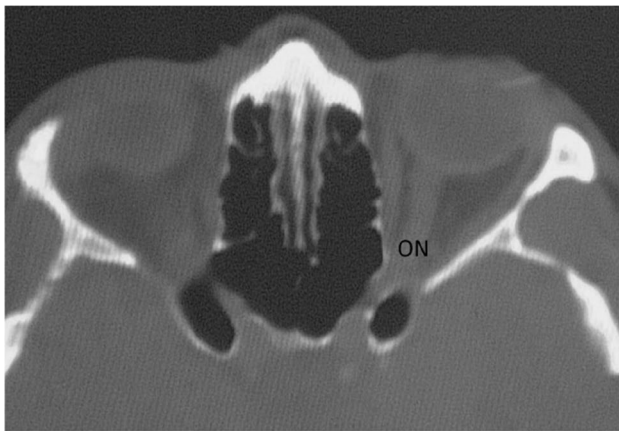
CT scan showing a free-floating optic nerve
